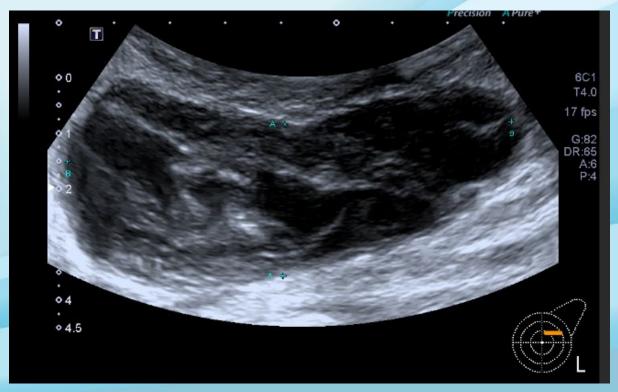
Ultrasound & mammogram showing a large lobulated anechoic /hypoechoic cystic lesion with few septations & peripheral echogenic foci
